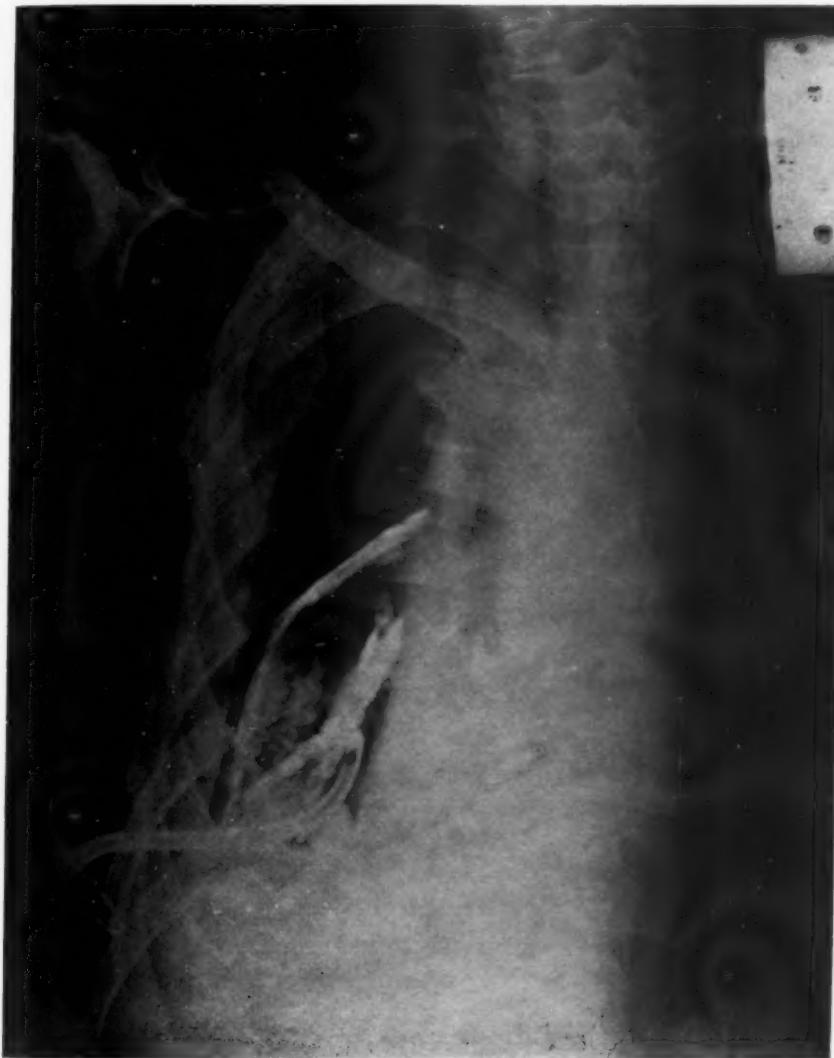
Roentgenogram. A bronchial fistula developed and the pleural cavity became secondarily infected. Drainage of the pus revealed that the layer of calcium had become separated en masse and lay free in the pleural cavity.
